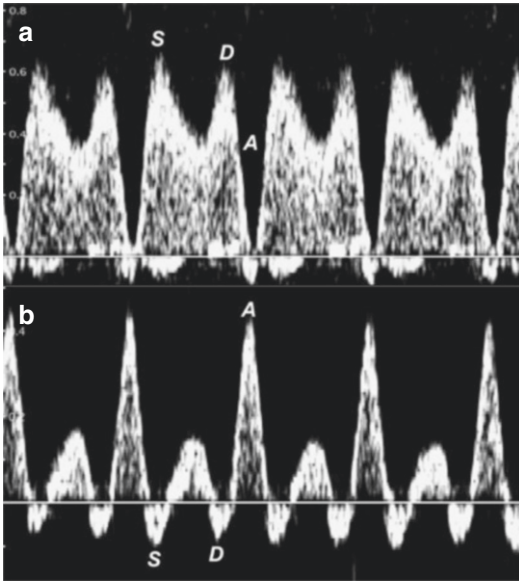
Doppler recording of the ductus venosus (a), and the left portal branch (b), in a fetus of 25 weeks' gestation with placental compromise. For anatomical references, see Fig. 5.16. The ductus venosus recording shows an augmented velocity deflection during atrial contraction (A) reaching the zero-line and beyond. The same wave recorded in the left portal branch is now a peak (A in b) and the entire wave mirrors the ductus venosus recording. The reason is that in the left portal branch, pressure wave and blood flow have same direction, while in the ductus venosus, pressure wave and blood flow are opposite. D Diastolic peak, S Systolic peak. (Modified from [57])
